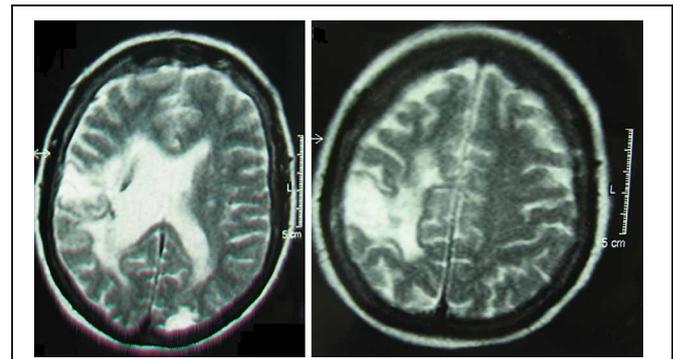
Magnetic Resonance images of EB’s brain lesion. Following the radiological convention, the right hemisphere is on the left side of the image.
